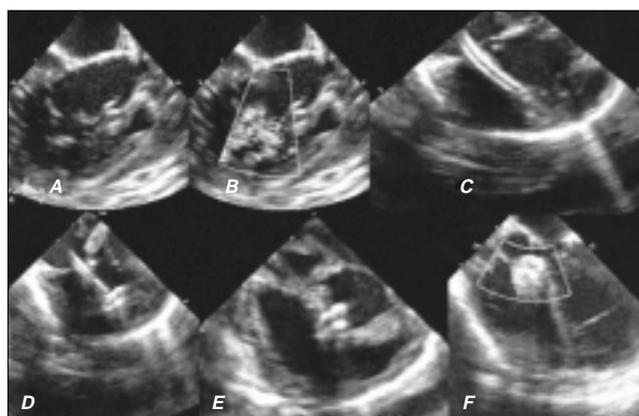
Transesophageal two-dimensional echocardiogram and color Doppler images of short and long axis views. (A) Perimembranous ventricular septal defect with aneurysm, (B) Aneurysm with two jets into right ventricle, (C) The long sheath deep in left ventricle, (D) Left ventricle disc deployed after sheath is withdrawn, (E) Right ventricular disc deployed and device in good position, (F) No residual flow across the device.
